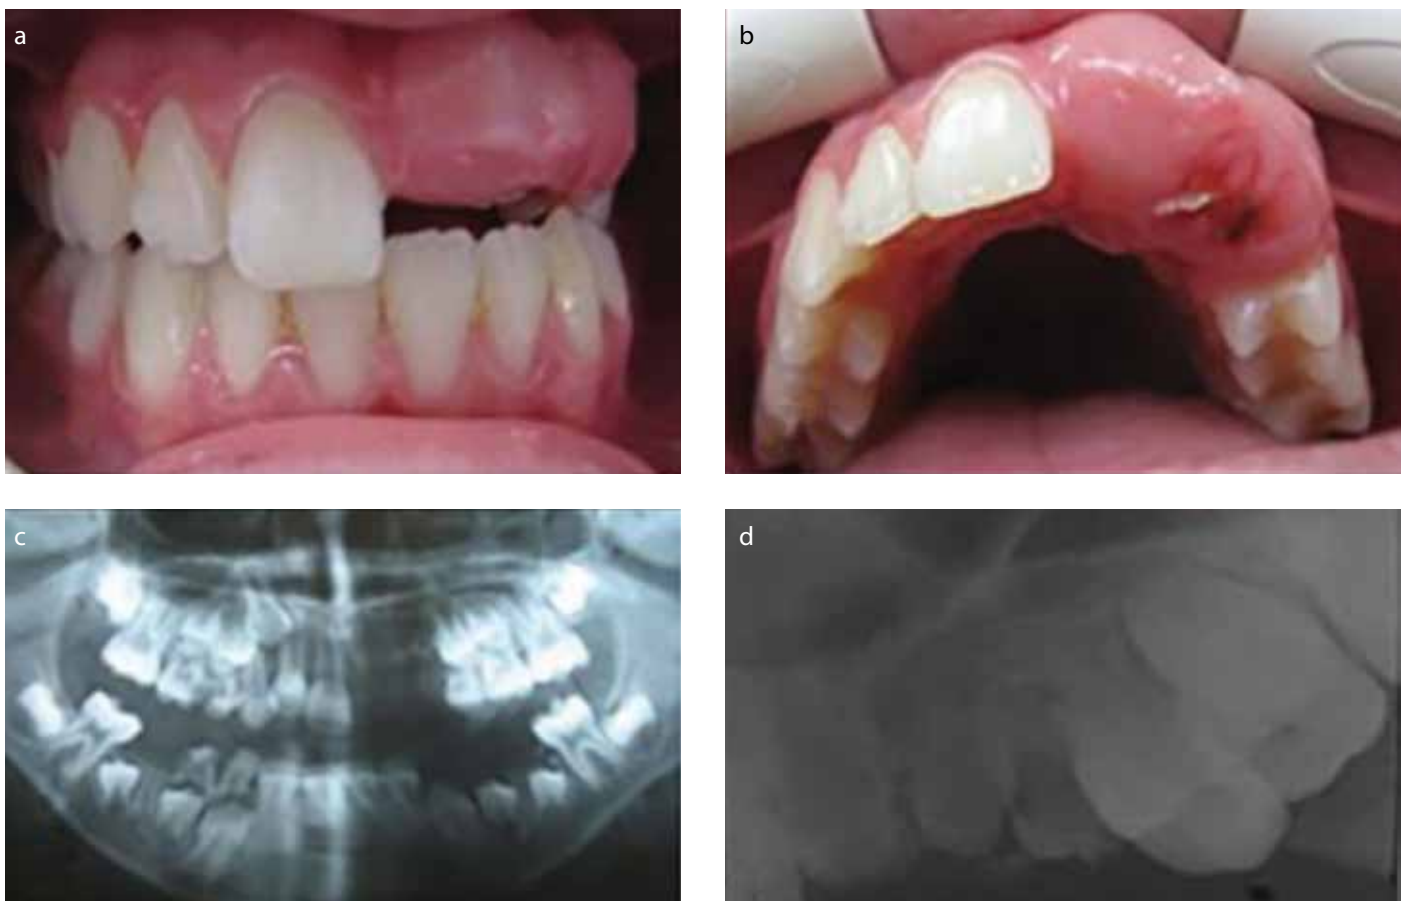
a-d. (a, b) Intraoral (c, d) radiographic view during the first presentation.
